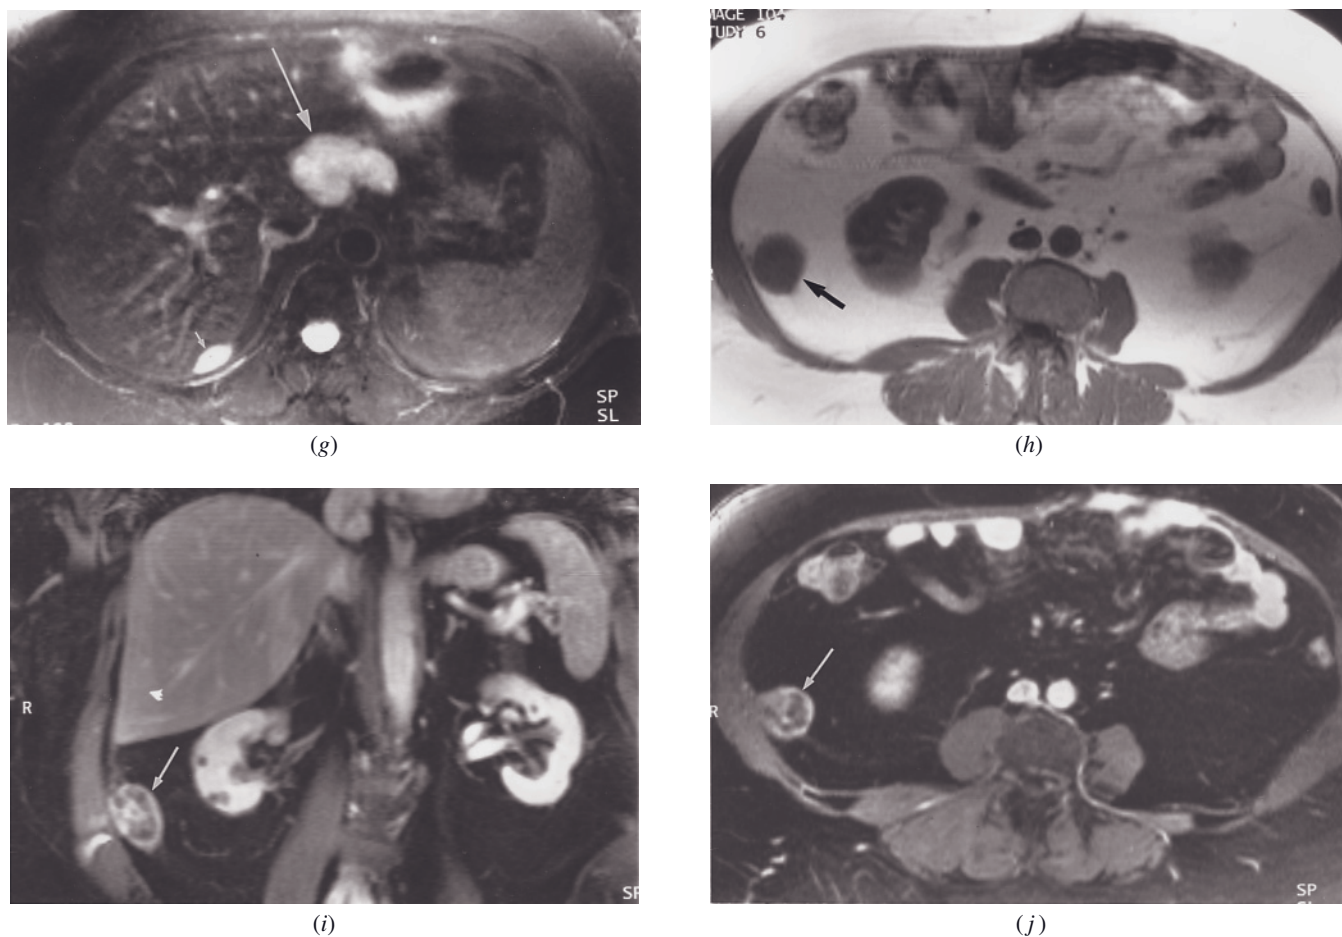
(Continued) T2-weighted fat-suppressed echo-train spin-echo (*g*) and SGE (*h*) images of the liver and interstitial-phase gadolinium-enhanced fat-suppressed SGE image in coronal (*i*) and transverse (*j*) planes of the midabdomen. A lobulated 4-cm peritoneal implant along the gastrohepatic ligament is moderately high in signal intensity (arrow, *g*) and contrasts well with moderately low-signal-intensity liver. A subcapsular liver metastasis is also present (small arrow, *g*) that demonstrates a characteristic biconvex lens shape indicating its subcapsular location. Noncontrast SGE image shows a 2-cm low-signal-intensity peritoneal metastasis (arrow, *h*) that contrasts well with high-signal-intensity fat. Gadolinium-enhanced fat-suppressed SGE images demonstrate heterogeneous speckled enhancement of the mass (arrows, *i, j*).
